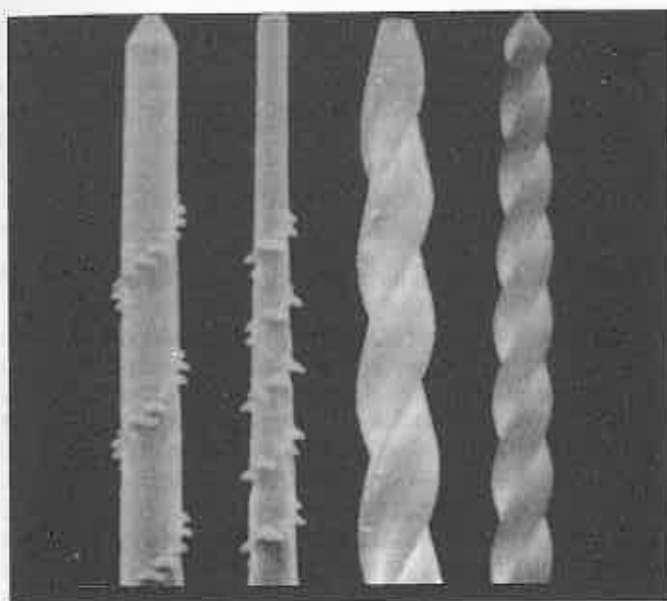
Files. Left - Shaper Sonic & Rispi Sonic Right - Ultrasonic K-Files
